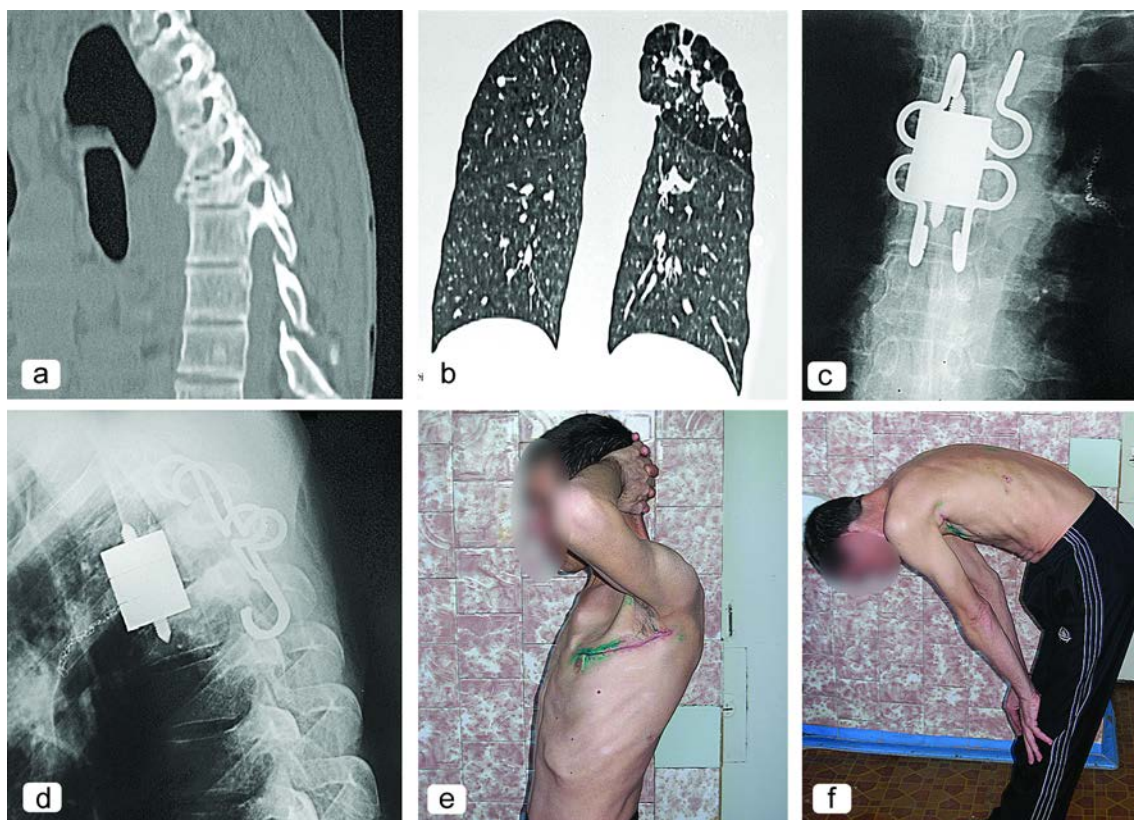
A 42-year-old patient with lung tuberculosis, tuberculous spondylitis of Th₄-Th₅ vertebrae, compressed Th₅ vertebral body: (a), preoperative CT scan of the spine; (b), preoperative CT scan of the lungs; (c, d), AP and lateral spondylograms 2 months after the surgery; (e, f), functional outcome 12 days after surgical treatment
